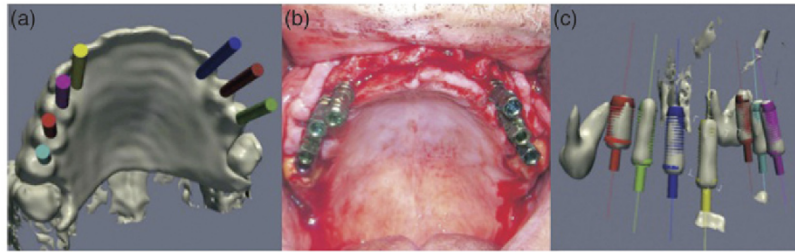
Patient-specific surgical guides fabricated via stereolithography can greatly improve the ultimate functional performance and design aesthetics of an implanted medical device. (a) CT scans and CAD modeling used to generate digital models of treatment planning guides; (b) implants placed using surgical guides fabricated via stereolithography; (c) demonstration of good match between planned implants (various colors) and actual placed implants (gray) [72].
